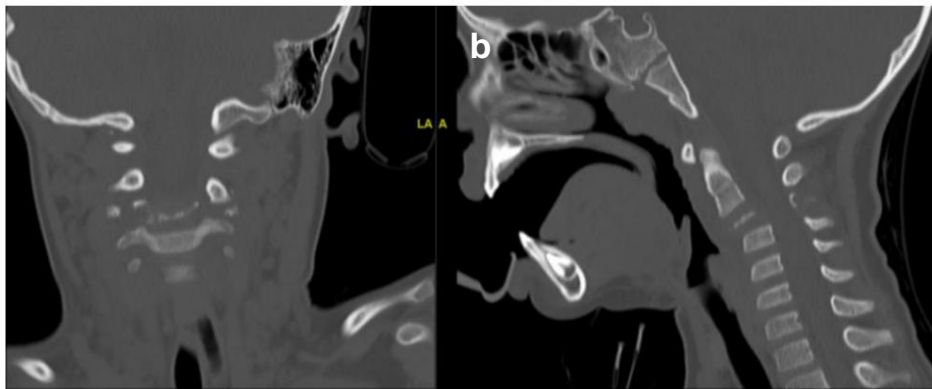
(a and b). CT of the cervical spine showing a lytic lesion of the vertebral body of C3 causing its flattening and collapse.
